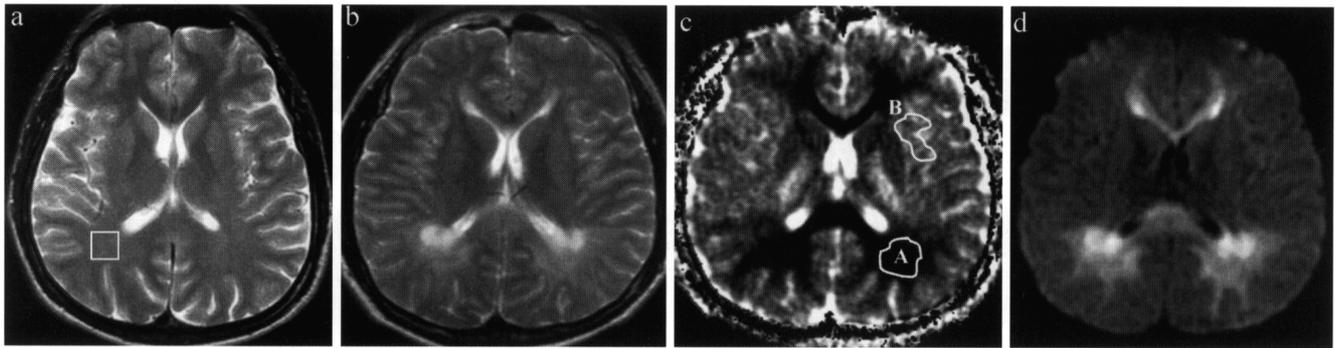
T2-weighted transversal MR images of a healthy volunteer (a) and a PKU patient (b). *ADC* map (c) and diffusion-weighted (d) MR image of the same PKU patient. Typical pathological lesions are visible in the periventricular white matter. Area A: The mean *ADC* of water measured in PKU lesions in periventricular white matter. Area B: Visibly uninvolved white matter and gray matter in the frontoparietal region. Areas of interest A and B were approximately 1 cm². Projection of the volume of interest for the MRS examination is marked in (a).
